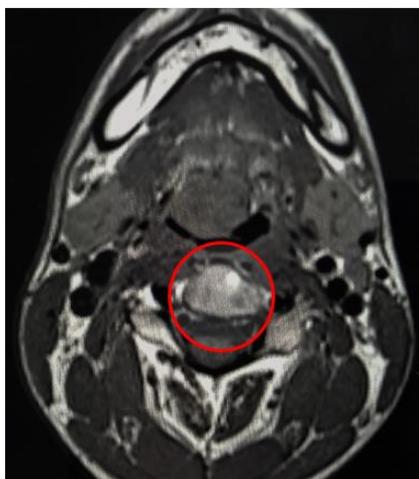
MRI Axial view Neck
